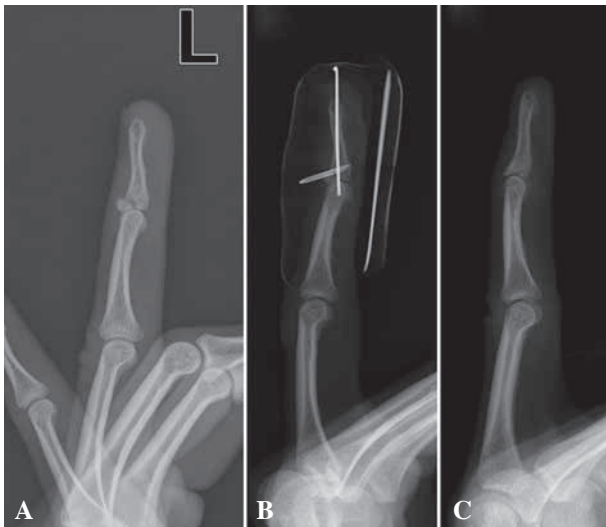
A 33-year-old male with a mallet fracture of the left ring finger. (A) Preoperative X-ray of the type IB mallet fracture. (B) The X-ray 1 week after surgery shows well-maintained reduction without displacement. (C) The X-ray 2 months after surgery shows complete bony consolidation.
